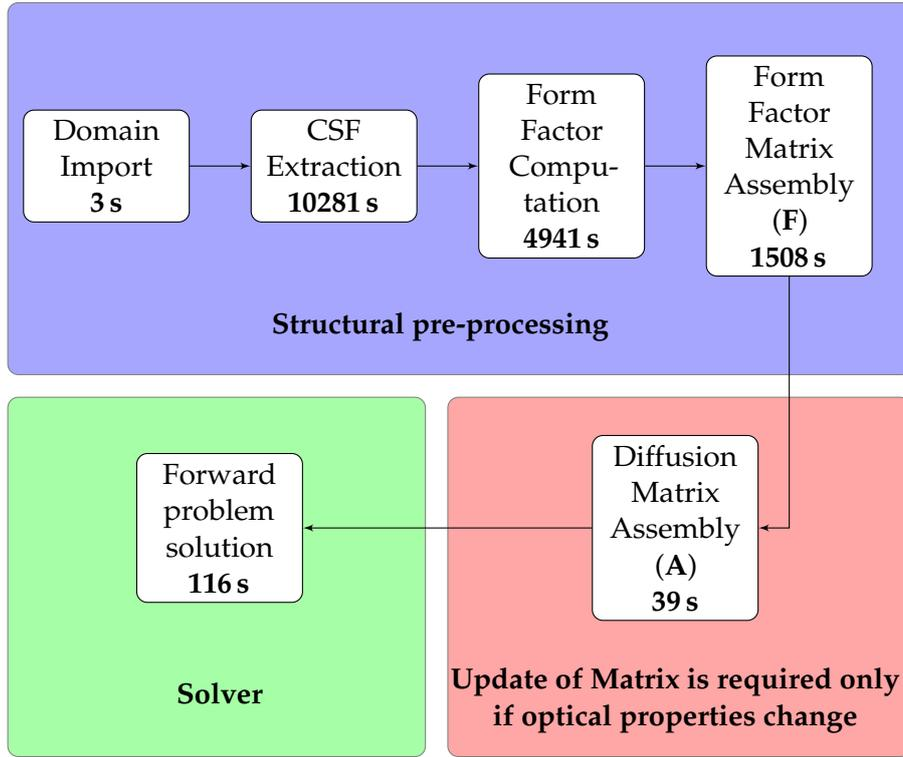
Time elapsing for forward problem solution in a complete human head domain derived from 3T structural MRI.
